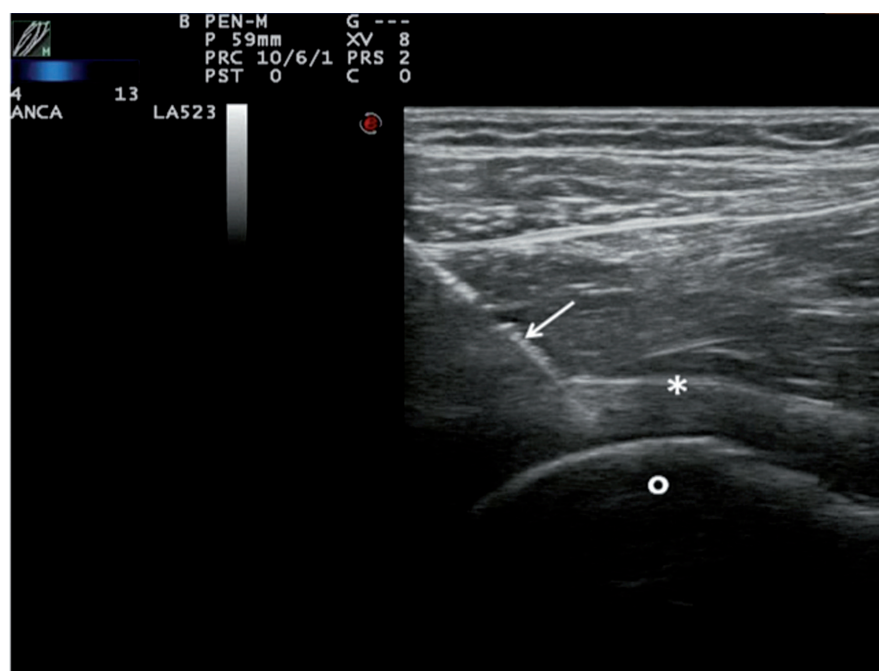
Ultrasound-guided hip intra-articular injection. The arrow indicates the needle inserted via the antero-superior approach into the joint capsule* on the femoral head°.
